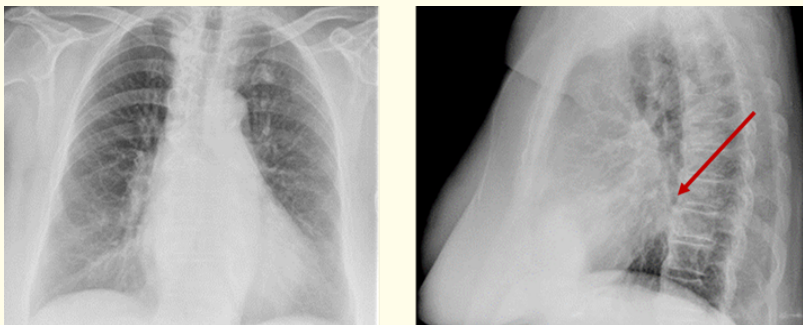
Preoperative chest X-ray before aortic valve replacement showing cardiomegaly.
